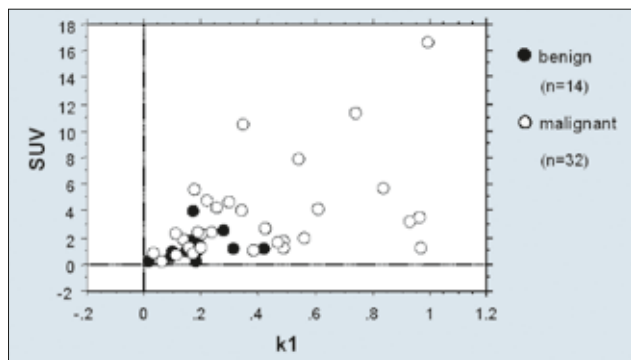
The relationship between k1 and SUV in primary lesions (n=46). The data demonstrate an overlap between malignant and benign disease in the low k1 and SUV area.
